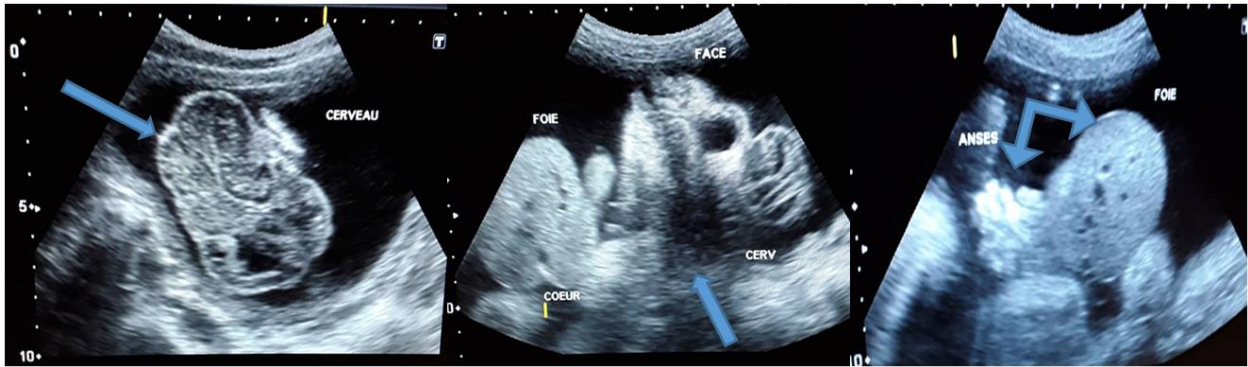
Morphological ultrasound in mode B objectifying the absence of the bones of the skull, the shortening of the cervical spine and evisceration of the digestive loops (arrows)
